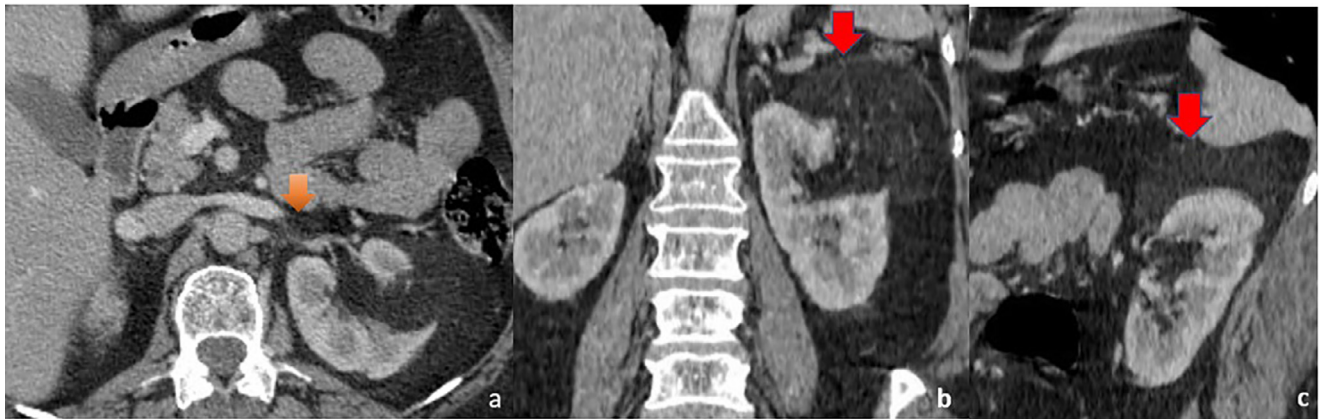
Renal angiomyolipoma. Contrast-enhanced CT Axial (a), Coronal (b), and sagittal (c) images showing peripheral fatty mass (70 x 77 x 67 mm) in left kidney (red arrows), expanding into the renal vein (orange arrow). (Colour version of the figure is available online.)
